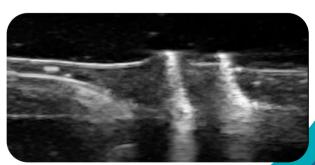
Coil in contact with vessel wall on ultrasound transverse view
